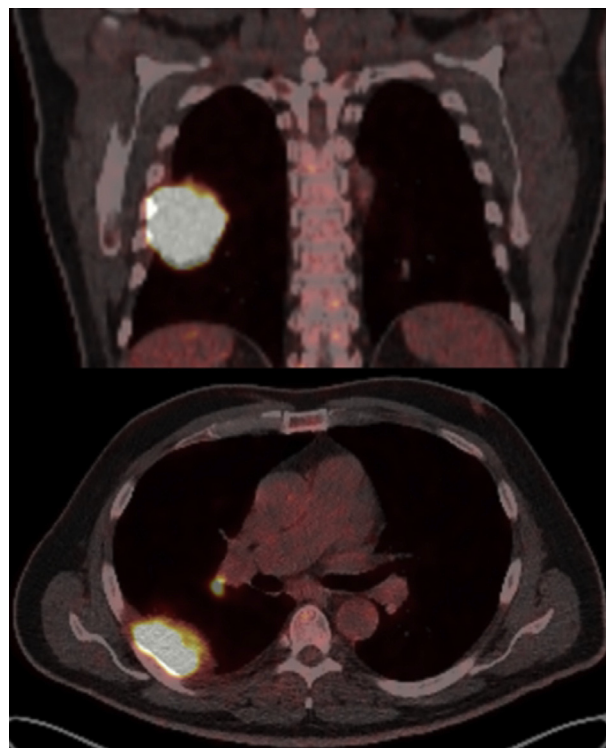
Example of the nomogram being used. Coronal and axial positron emission tomographic-computed tomographic images of a Dutch male patient with a cT4 N1 M0 squamous cell carcinoma of the right lower lobe. An open lobectomy was performed. The nomogram sum score is 6.3 points, which translates into an individual risk of 30% for incomplete resection. Pathology after lobectomy with thoracic wall resection revealed R1 resection.
